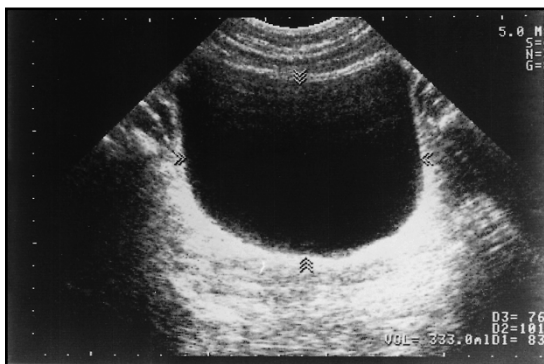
Postmicturition ultrasound scan of the bladder in a woman with MS. The residual was calculated to be 333 ml.
